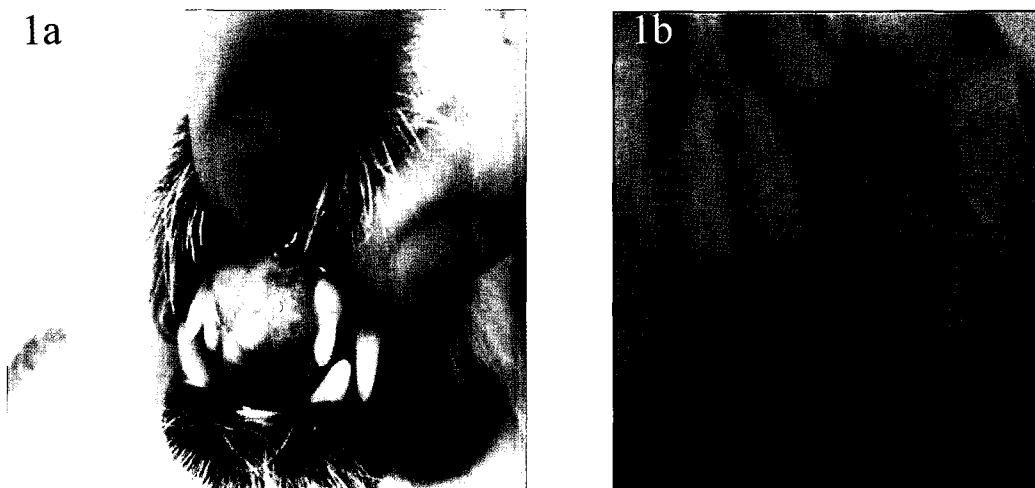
Gross examination of an exuberant, protruding mass along the rostral maxilla. Note the dental involvement and malocclusion; 1b. Radiograph showing malocclusions of the first and second upper incisors. The mass affected the superficial and deeper layer of the gingiva
